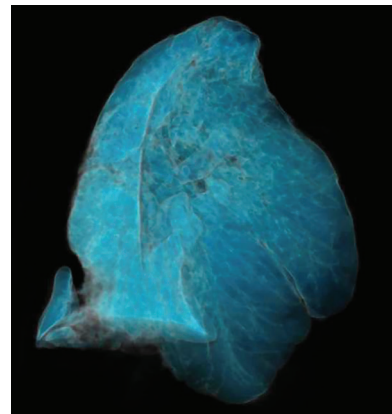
Three-dimensional computed tomography scan shows herniated lung.
